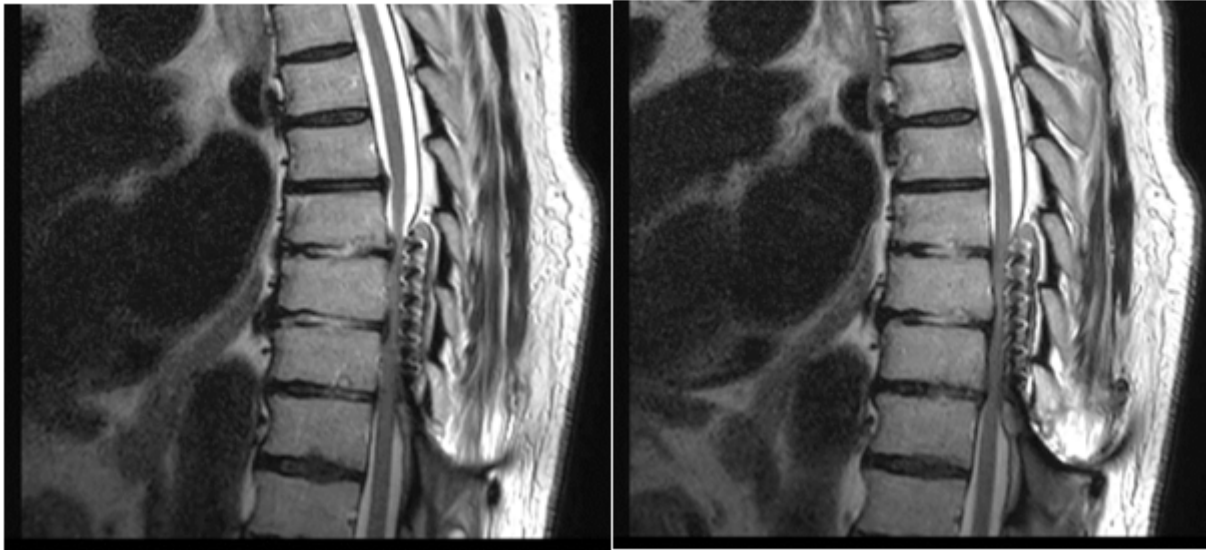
spinal cord MRI showing signs of compression under the electrode, without a visible hematoma.
